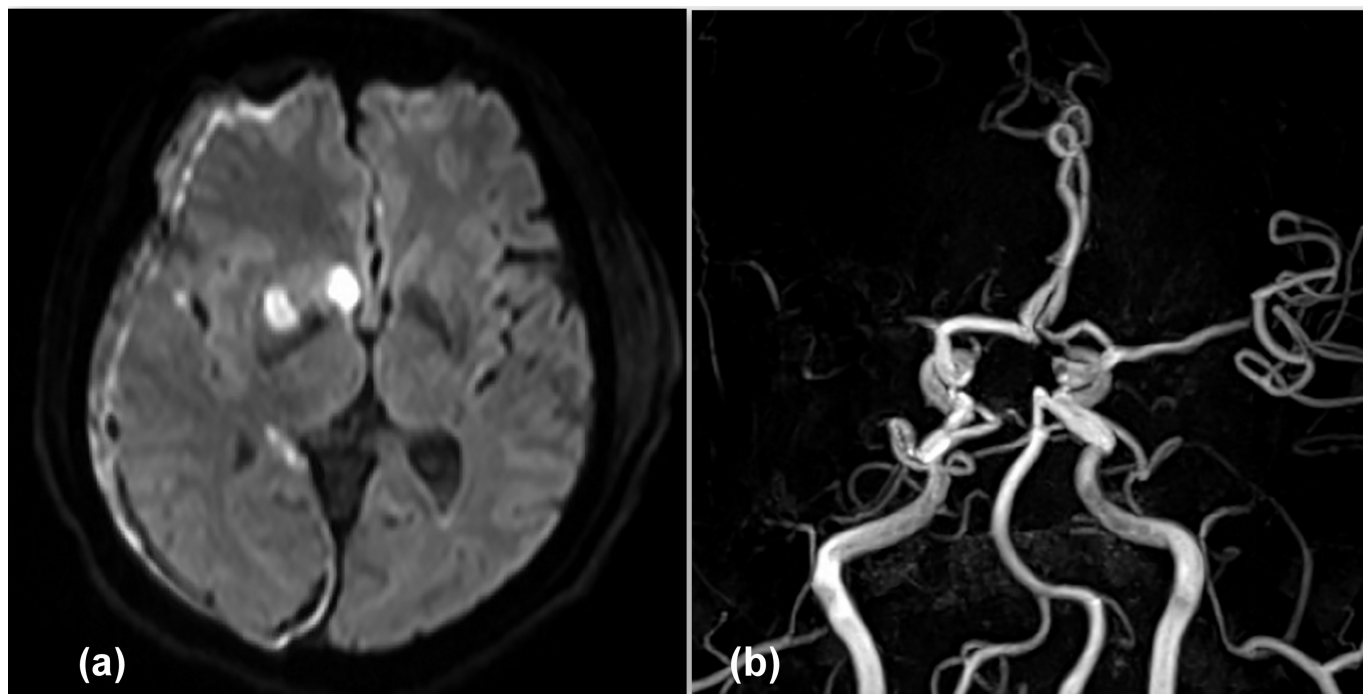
Magnetic resonance (MR) image of the brain examined soon after initial CT. (a) Diffusion-weighted MR image showing high signal intensity with corresponding low-density lesion in CT, which indicate that these lesions are acute cerebral infarctions. (b) MR angiogram showing the occlusion of the proximal horizontal portion of the right middle cerebral artery.
